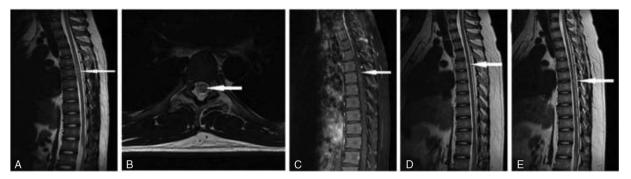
MRI of myelitis lesion with spinal cord involvement in a Behçet disease patient. A, T2-weighted MRI scan showing high signal intensities from 4 to 7 thoracic vertebral body level. B, Axial T2-weighted images demonstrating the entire diameter of the extensive cord lesion. C, After 2 months, T2-weighted magnetic resonance imaging scan showing high signal intensities in the fifth thoracic vertebral level. D and E, Four months after discharge, T2-weighted MRI scan indicating high signal intensities in the fifth thoracic vertebral level. D and E, Four months after discharge, T2-weighted MRI scan indicating high signal intensities in the spinal cord of 6 to 7 thoracic vertebral levels. MRI = magnetic resonance imaging.
